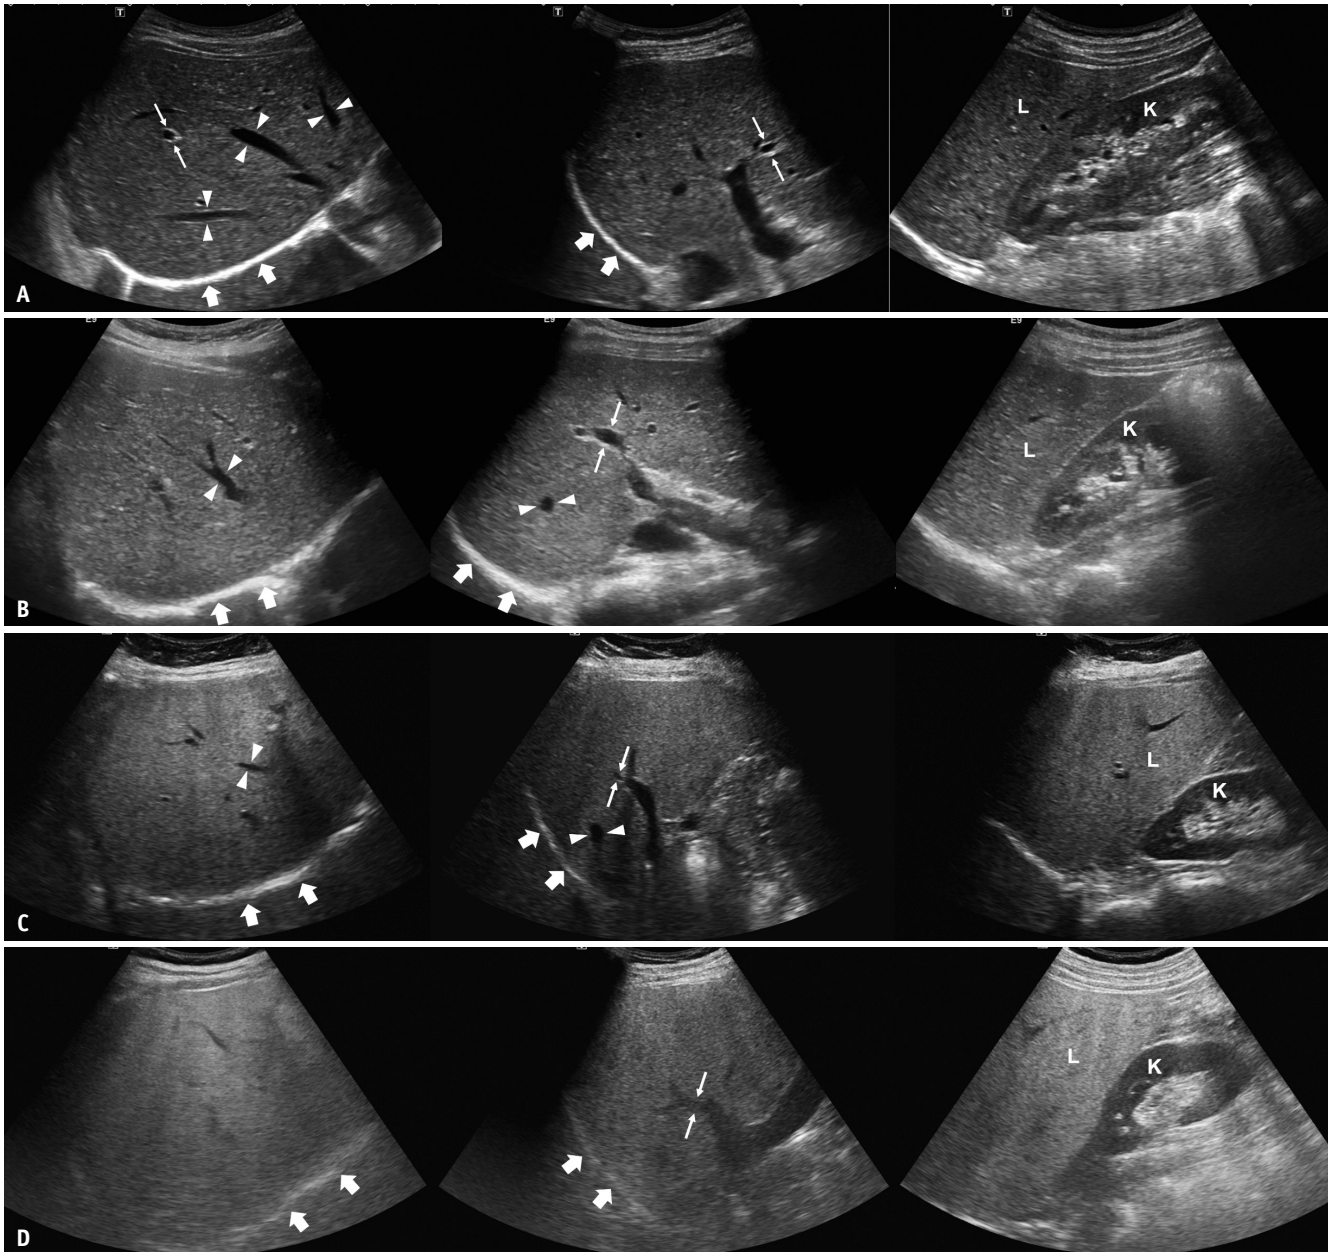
Conventional ultrasound images of patients with different degrees of hepatic steatosis in subcostal view (left), intercostal view (middle), and longitudinal view with right kidney (right).
